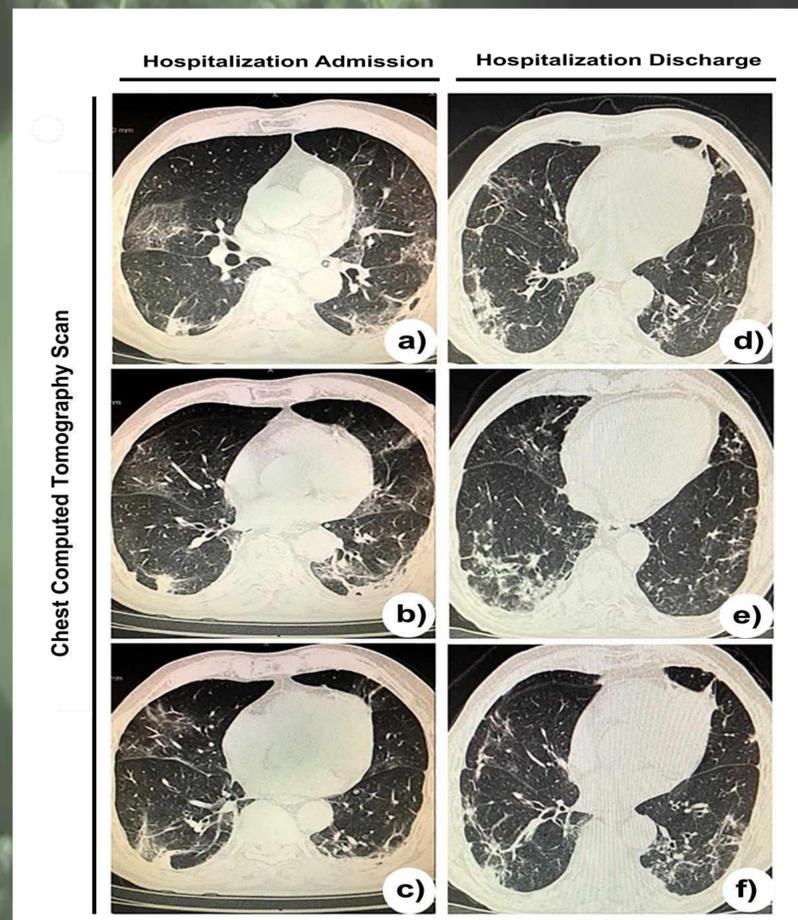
Chest CT alterations found in case patient on hospital admission (a, b, c) and on discharge (d, e, f). Areas of ground-glass opacities on lung parenchyma with bilateral distribution and predominance on right upper and middle lobes agree with active COVID-19 lung affection (a, b, c). This characteristic is not observed after patient clinical improvement, with predominance of periphery pulmonary consolidations and fibrous stripes (d, e, f).
